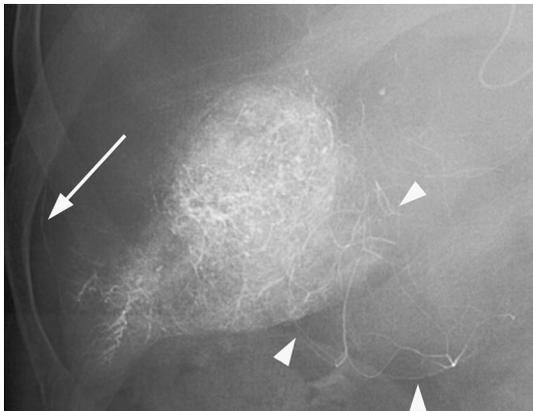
Anastomosis between the hepatic arteries and cystic arteries via the capsular arteries in a patient with hepatocellular carcinoma. The anterior inferior branch of the right hepatic artery was selectively embolized using iodized oil and gelatinous particles. Iodized oil accumulated in the capsular artery (arrow) as well as the liver parenchyma and the tumor were seen in this post embolization radiograph. In addition, the cystic arteries was also observed (arrowheads) due to the regurgitation of iodized oil in the liver parenchyma via the capsular arteries
